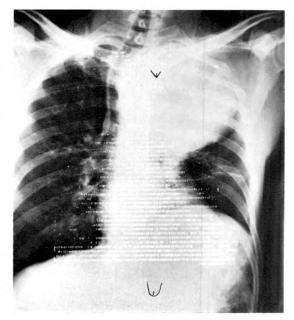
Solenoid print scan data are superimposed upon matching 6 foot, anteroposterior, recumbent, midrespiration roentgenogram of a 51 year old man with rapidly growing left superior sulcus tumor mass, later shown to represent anaplastic carcinoma. Absence of blood pool is compatible with the diagnosis of solid tumor or aneurysm filled with clot. (Reproduced by permission from J.A.M.A.4)
